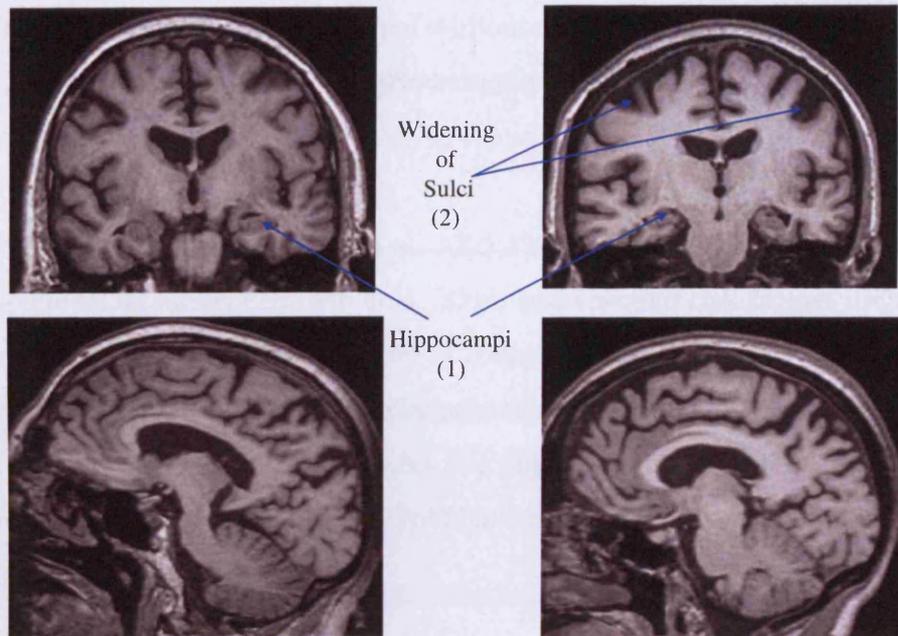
Coronal and sagittal views on MRI of a healthy control (A) and a subject with AD (B) demonstrating the characteristic macroscopic changes of AD, (1) atrophy of hippocampi with attendant temporal lobe atrophy and (2) with disease progression, global atrophy with expansion of cerebrospinal fluid spaces and sulcal widening.
